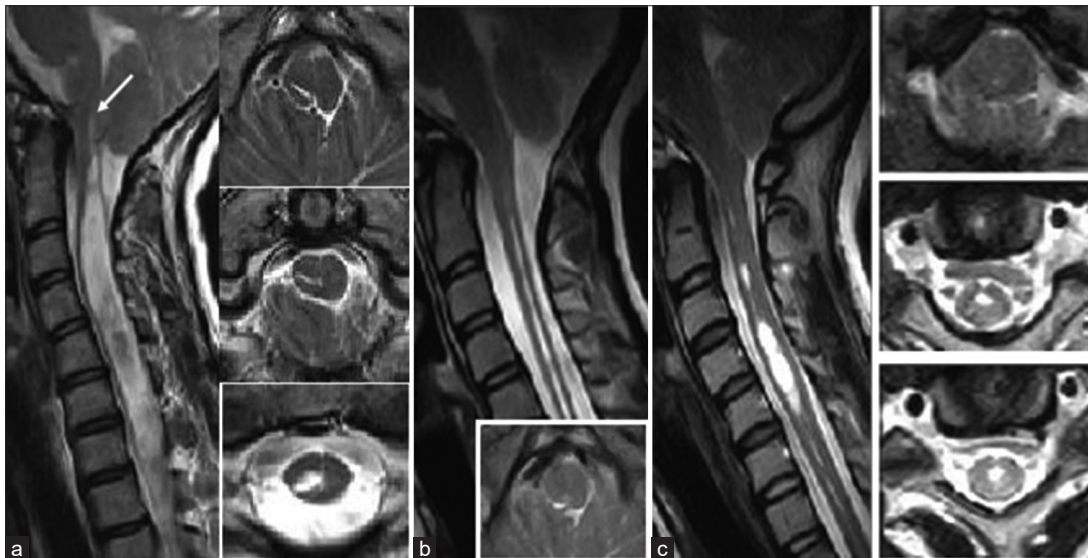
(a) Case 1: Preoperative magnetic resonance imaging (MRI) scans of the cervical spine. T2-weighted MRI scan in the sagittal plane, showing a Chiari type I malformation (CMI) and a holocord syrinx with syringobulbia (arrow). An axial MRI scan was obtained at the foramen magnum level, demonstrating the slit-like syrinx in the right dorsal region of the lower medulla. (b) Case 1: Postoperative MRI scans of the cervical spine obtained 3 months after surgery. T2-weighted MRI scan in the sagittal plane, demonstrating decompression of medulla oblongata and cerebellar tonsils at the foramen magnum. The syringobulbia has collapsed. The cervical syringomyelia is slightly decreased in size but remains and (c) Case 2: MRI scans of the cervical spine. T2-weighted MRI scan in the sagittal plane, showing a CMI and a syrinx from the high cervical to the C3-5 level. Axial MRI scan was obtained at the foramen magnum and C3-5 level, demonstrating the syrinx in the mid-ventral region.
